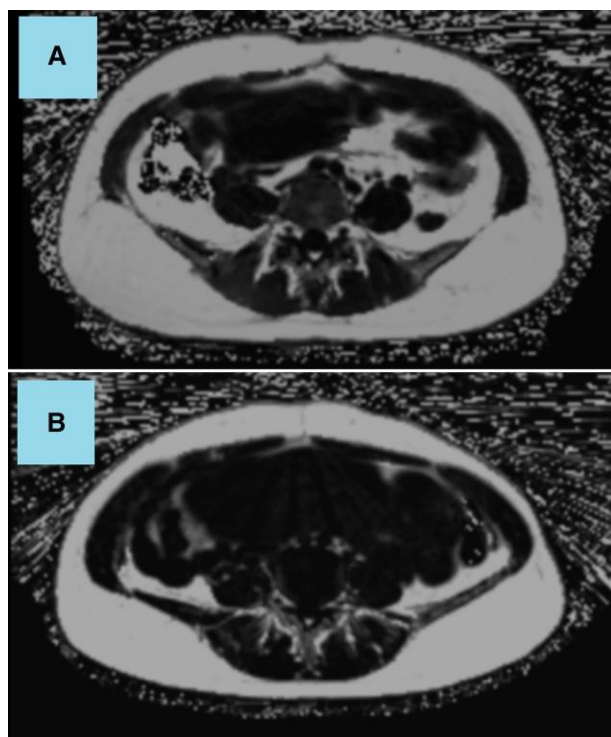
MRI images. Comparison of representative MRI images of two different subjects in the axial plane. A patient with gestational diabetes (GDM) is shown in the top image (A), versus a patient who did not develop GDM in the bottom image (B), at similar axial MRI level. Both patients had a pre-pregnancy BMI in the Normal weight, yet visceral adiposity is visibly higher in the GDM patient (A).
